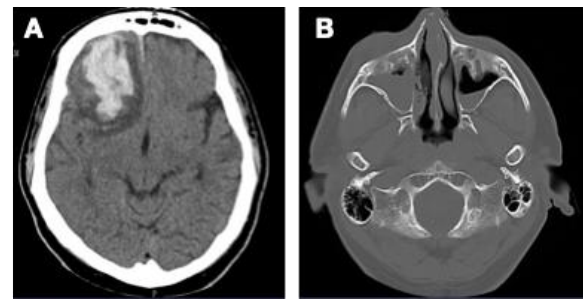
Axial computed tomography scan showing right frontal lobe intraparenchymal hemorrhage with edema (A) and bilateral maxillary sinusitis with erosion of medial wall of right maxillary sinus (B).
